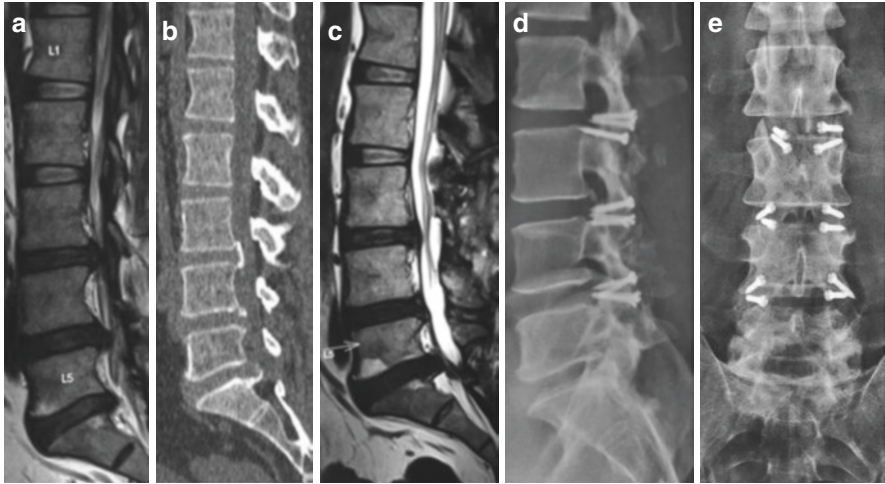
Images showing lumbar transarticular screw fixation. (a) T2-weighted MRI showing degenerative changes in the lumbar spine. (b) CT scan of the lumbar spine. (c) Postoperative MRI (3 months after surgery) showing reversal of the degenerative changes. (d) Lateral X-ray showing the double insurance transarticular screw fixation. (e) Anteroposterior view of radiograph showing the fixation
